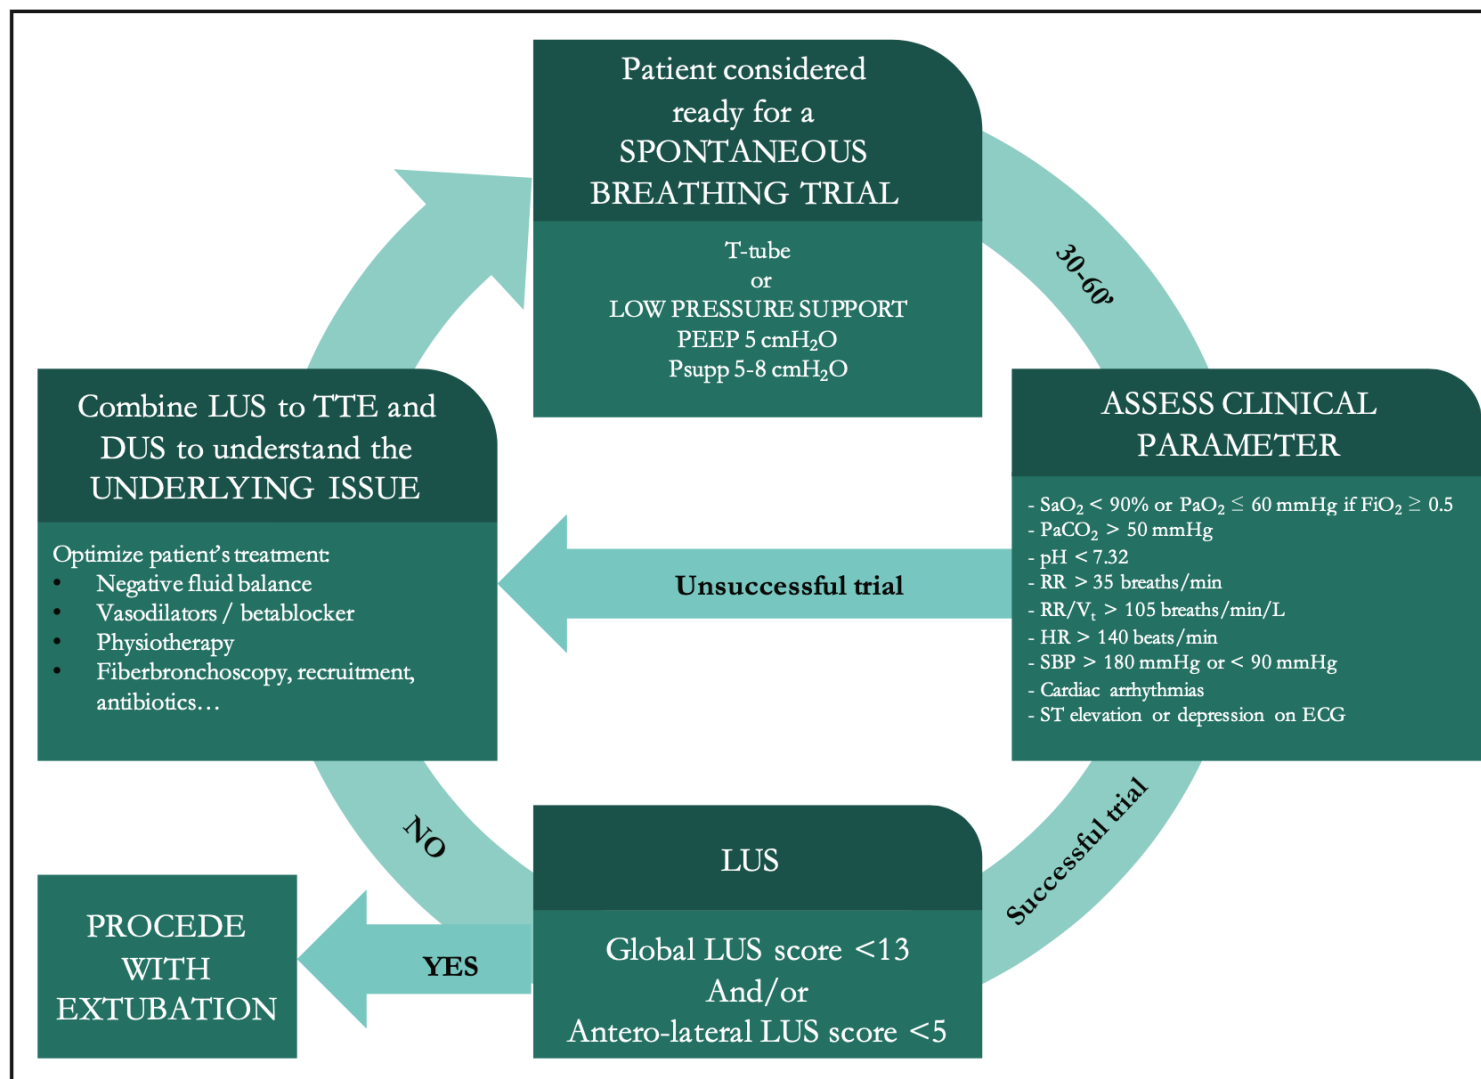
Combined clinical and ultrasound algorithm for weaning assessment. PEEP, positive end expiratory pressure; Psupp, pressure support; SaO₂, arterial oxygen saturation; PaO₂, arterial partial pressure of oxygen; PaCO₂, arterial partial pressure carbon dioxide; RR, respiratory rate; V_t, tidal volume; HR, heart rate; SBP, systolic blood pressure; LUS, lung ultrasound score; TTE, trans-thoracic echocardiography; DUS, diaphragm ultrasound.
